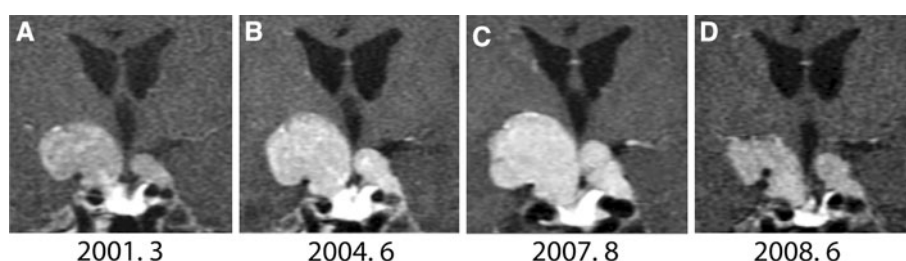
The change in sellar mass according to medication. The patient had been taking bromocriptine after undergoing transsphenoidal adenomectomy in November 1999. Bromocriptine was administered until August 2005. An MRI (a) in March 2001 showed the remaining suprasellar mass after subtotal resection. An MRI (b) in June 2004 showed a recurrent tumor in the right suprasellar and left
